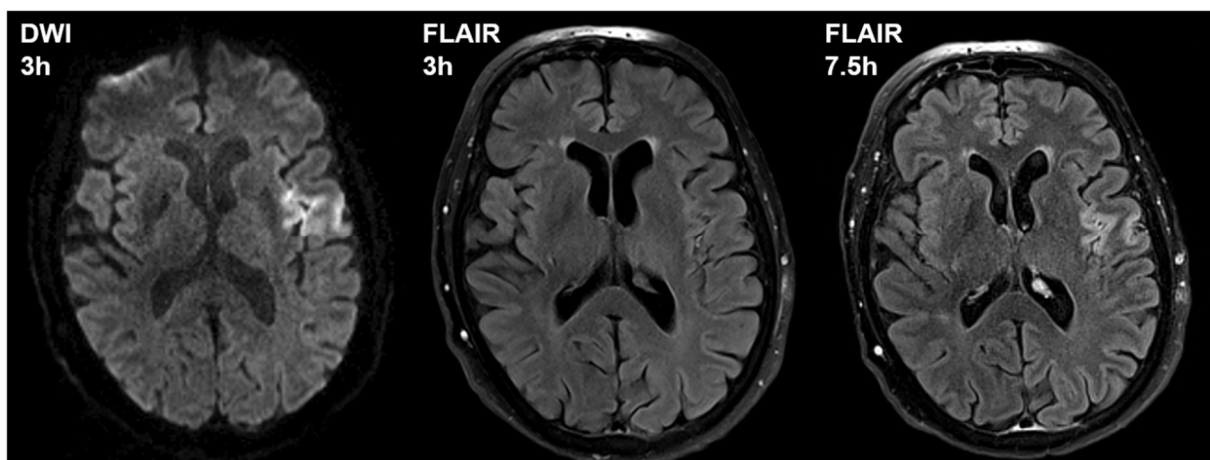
Two consecutive scans (3 hours and 7.5 hours after symptom onset, respectively) in a patient with a left-sided middle cerebral artery (MCA) stroke. DWI clearly shows the largely cortical ischemia at the earlier time point (signal increase in the left insula and operculum) whereas it is not yet visible on the corresponding FLAIR acquired during the same session (DWI-FLAIR mismatch), requiring several hours more for the T2 signal to evolve and become a DWI-FLAIR match.
